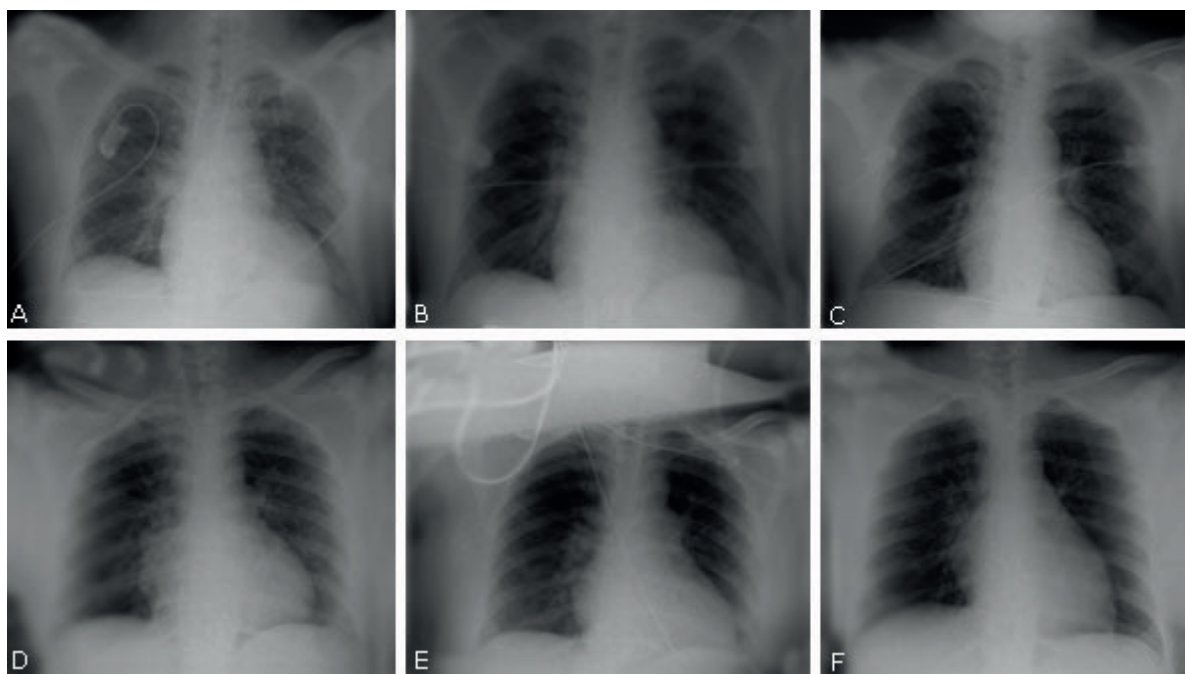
The serial thorax X-rays show a significant recovery of two patients with COVID-19 after a treatment with itolizumab.
